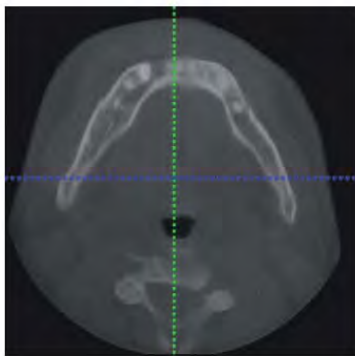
Preoperative computed tomography scan showing the tumour located in the proximity of the right first premolar with its lingual expansion as well as the mandibular body distention in buccal direction.
